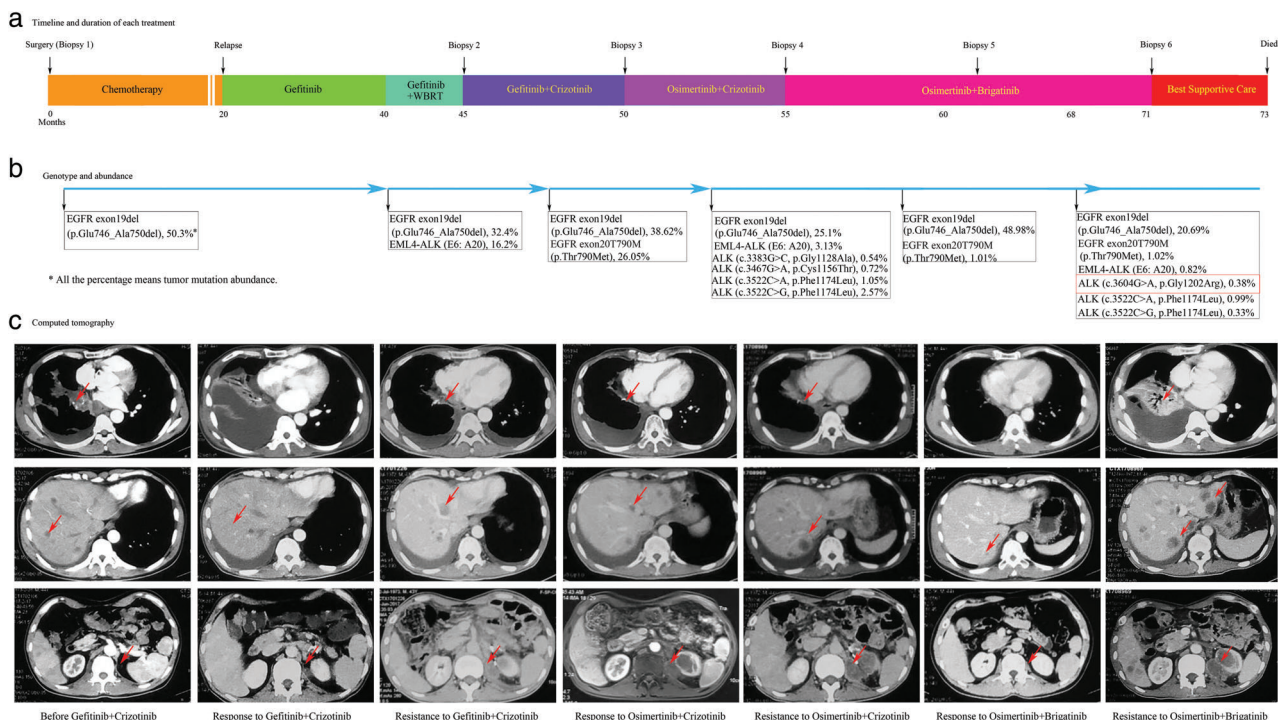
Genotype and duration time of each treatment. (a) The various treatments of the lung as well as the duration of each treatment. (b) The phenotypes and the abundance of mutation detected by next generation sequencing under the various treatments. (c) Computed tomography images of the patient’s metastatic liver, lung, and adrenal gland disease before he received gefitinib (G) + crizotinib (C), response to G + C, resistant to G + C, response to osimertinib (O) + C, resistant to O + C, response to O + brigatinib (B), respectively (G, 250 mg oral once daily; C, 250 mg oral twice daily; O, 80 mg oral once daily; B, 180 mg oral once daily). The red arrows show pulmonary nodules and metastasis. WBRT, whole brain radiotherapy.
